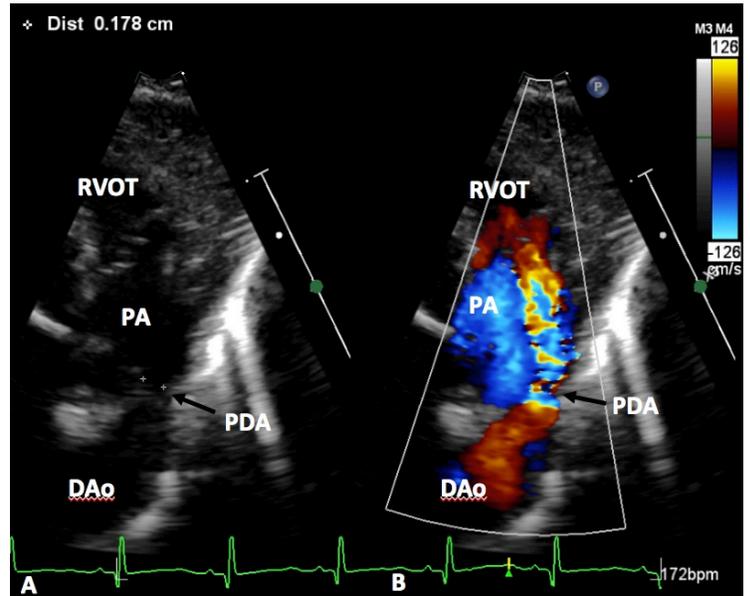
Echocardiographic frames from the parasternal short axis view demonstrating measurement of minimal diameter of the PDA. The color flow signal in B is deleted and 2-dimensional (2D) minimal ductal diameter measured in A. DAo, descending aorta; PA, pulmonary artery; RVOT, right ventricular outflow tract.
